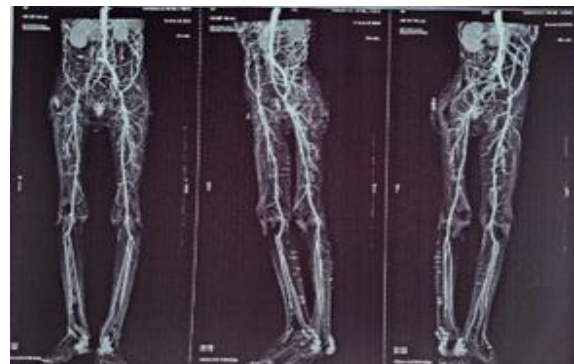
CT angiography with three-dimensional volume rendered reconstruction showing diffuse atherosclerotic involvement of bilateral lower limb arteries, with significant luminal narrowing in the common and superficial femoral arteries, more pronounced on the right side. Distal right sided arteries show reduced contrast opacification suggestive of thrombosis, while left-sided arteries are preserved (Case 2).
